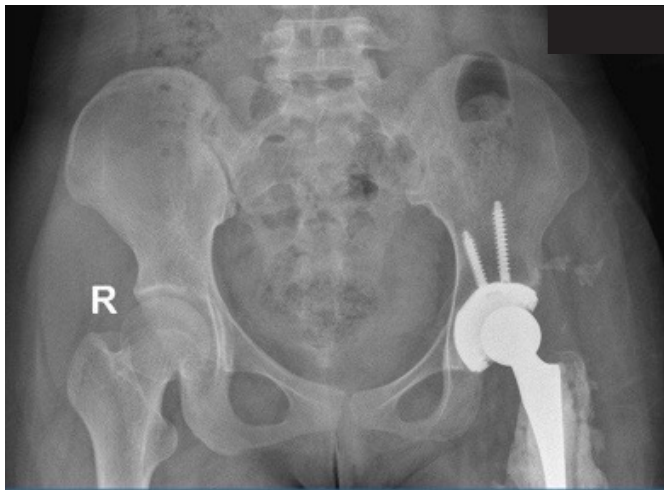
Radiographs of 33 months after rTHA pelvic x-ray (A) and AP and axial hip x-ray (B). Radiographs of 24 months after rTHA from AP (C) and axial hip (D).
